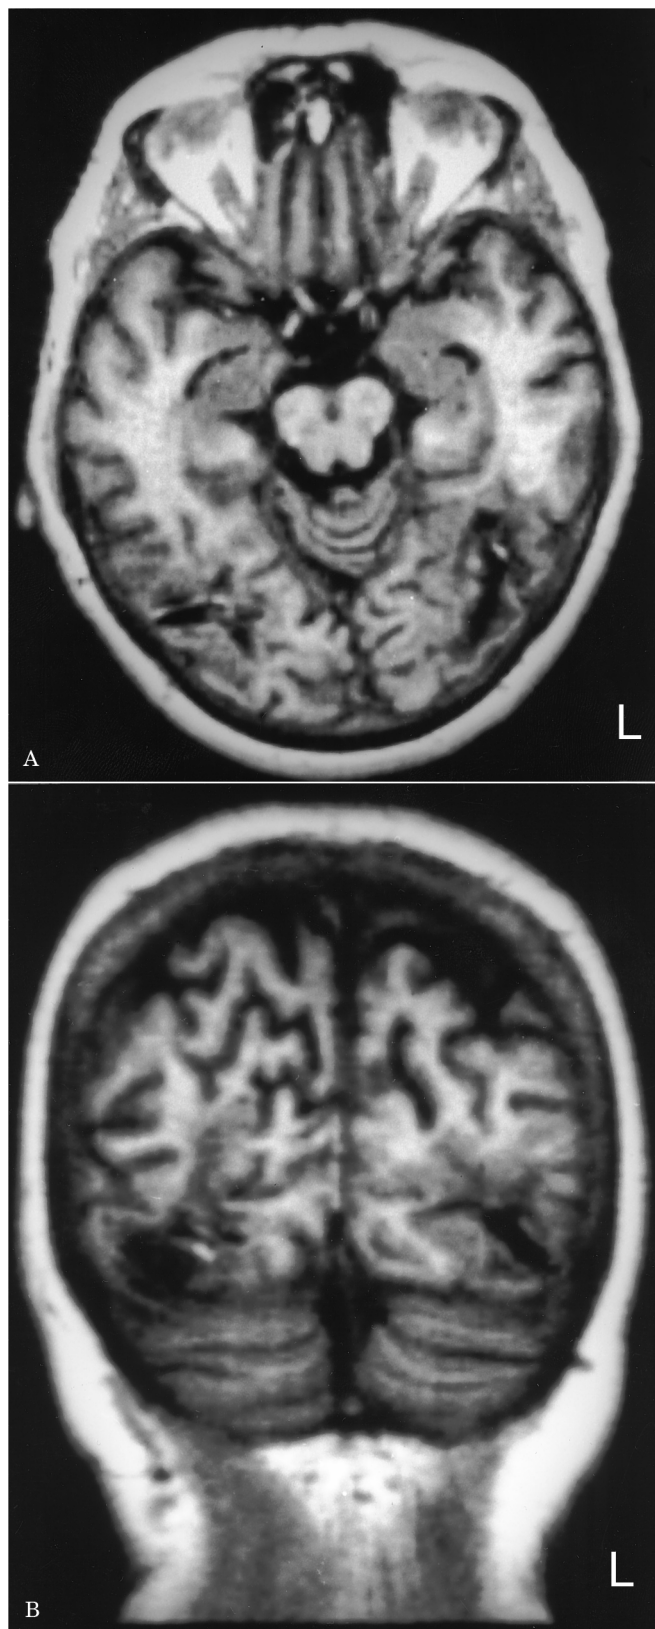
MRI. Transversal (A) and coronal (B) T1-weighted sections showing the first left hemispheric lesion and the second right hemispheric lesion.
